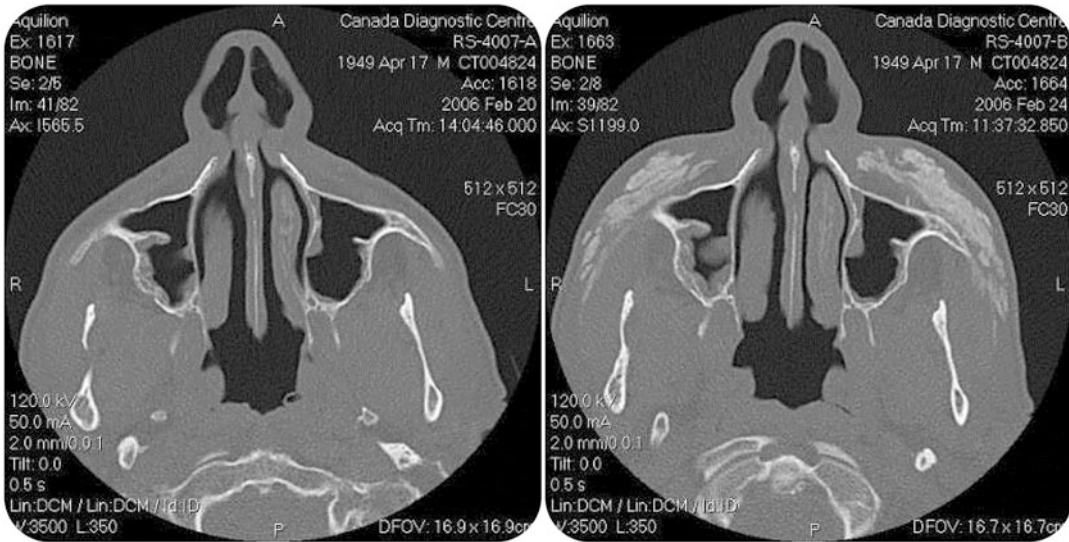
Imaging of CT scan pre and post CaHa
